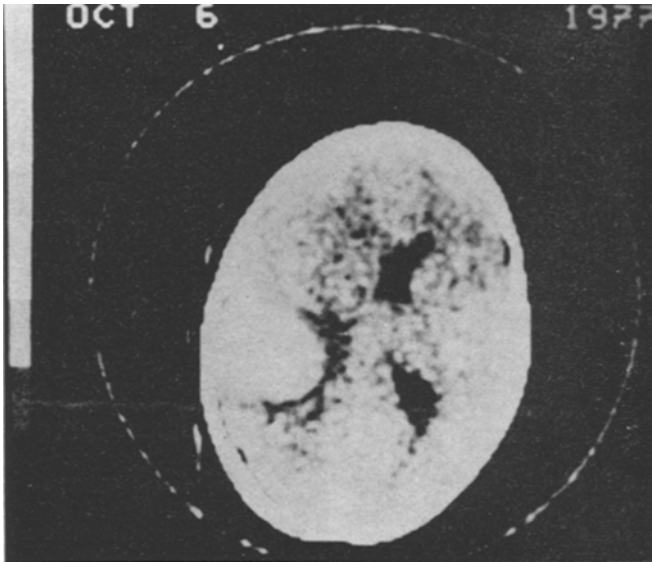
CT scan (6 October 1977) showing a left insulo-parietal haematoma
